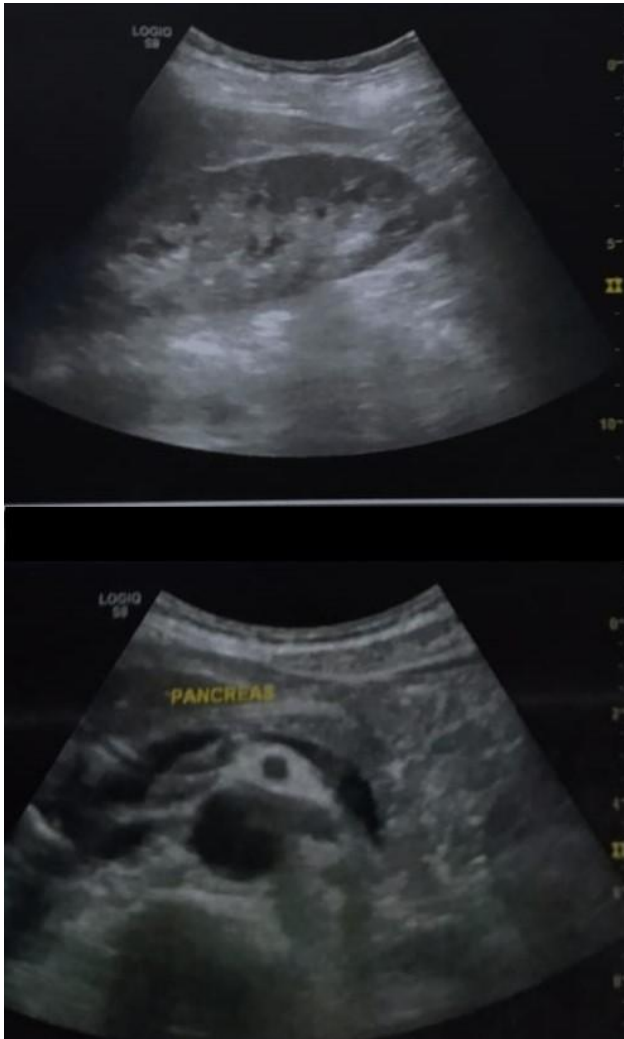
Abdominal ultrasound images showing...
